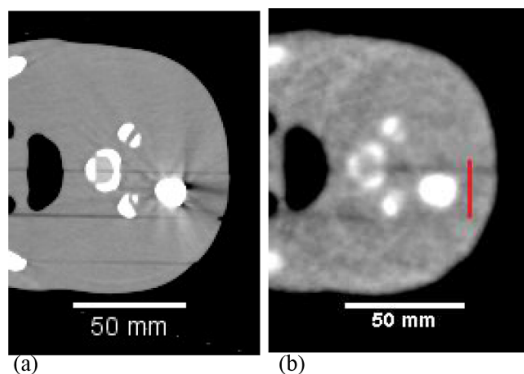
Close-up view, with enhanced contrast, of the titanium prosthesis region: (a) x-CT shown in figure 7; (b) pCT shown in figure 6(a). Red line indicates the ROIs used to quantify the standard deviation of the HU and RSP values.
